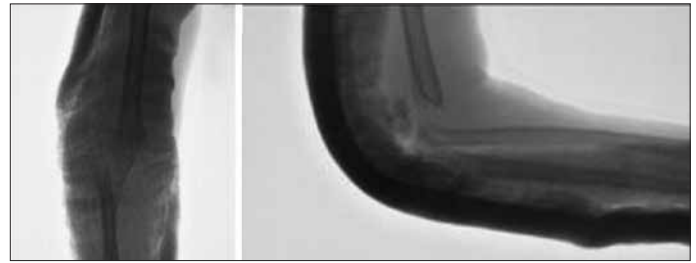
Preoperative supracondylar fracture X-rays (AP and lateral)
